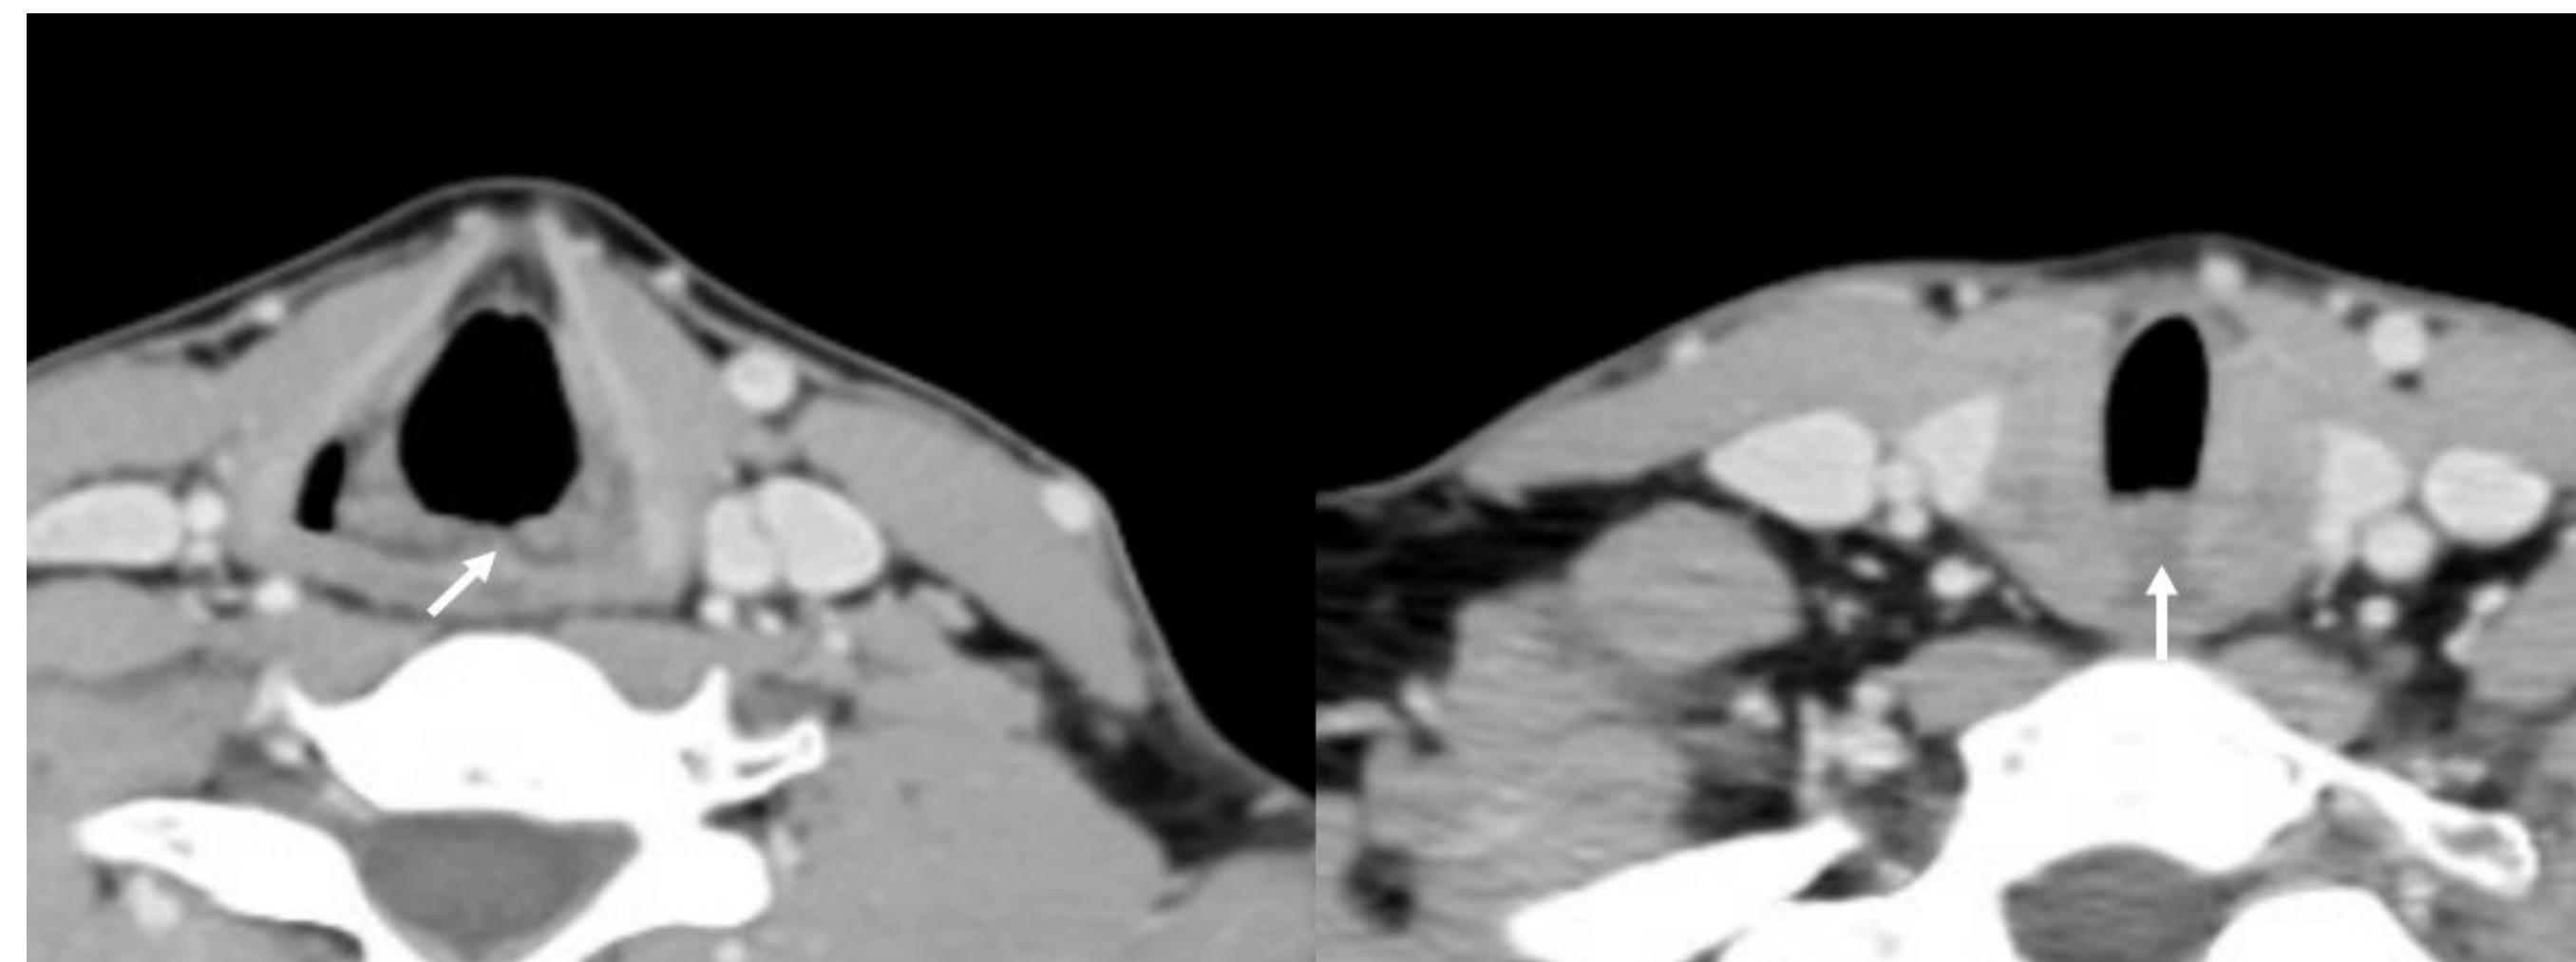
CT imaging demonstrating dehiscence of the muscular wall of the posterior larynx and tracheoesophageal party wall (white arrows).
